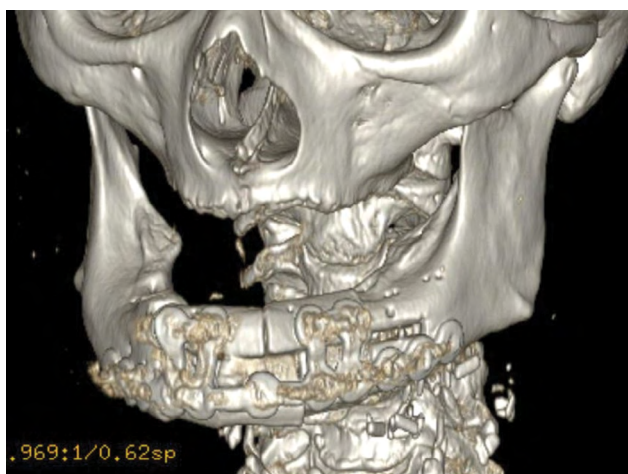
Postoperative computed tomography (day 10).
